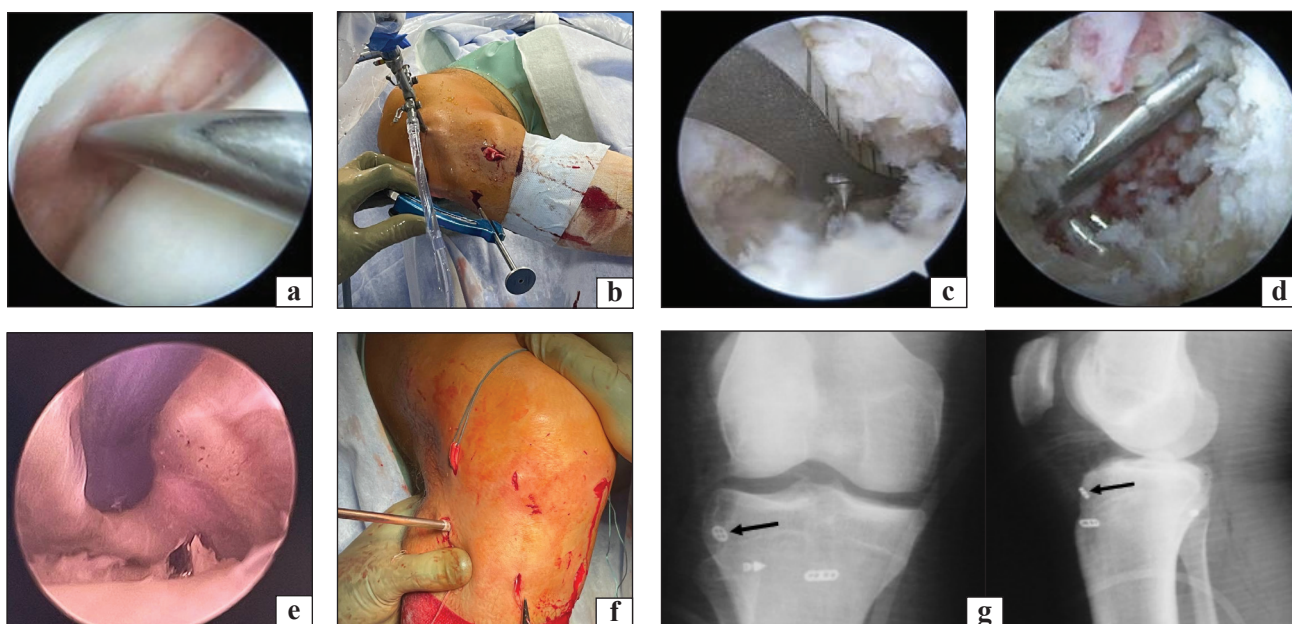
Stages of endoscopic reconstruction of the popliteal tendon in a patient with ACL injury: a) diagnostic probe under the external meniscus; b, c) installation of the conductor; d) drilling PliP Cutter 7.0 mm channel; e) removal of the conductor; f) installation of the graft g) postoperative radiography, the arrow shows the graft fixator
